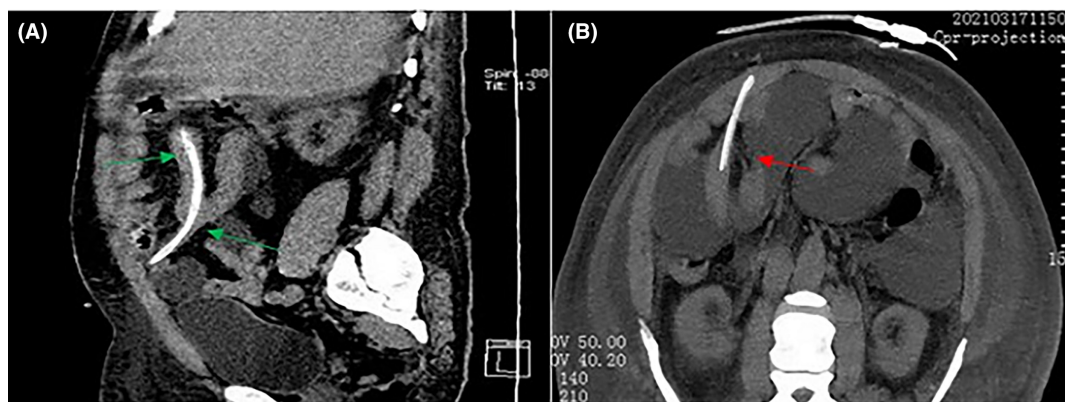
During the second peritonitis hospitalization, computed tomography showed that the catheter penetrated the small intestine. (A) Sagittal section: The catheter enters the small intestine (arrow). (B) Coronal section: The catheter passes through the intestinal wall (arrow).
